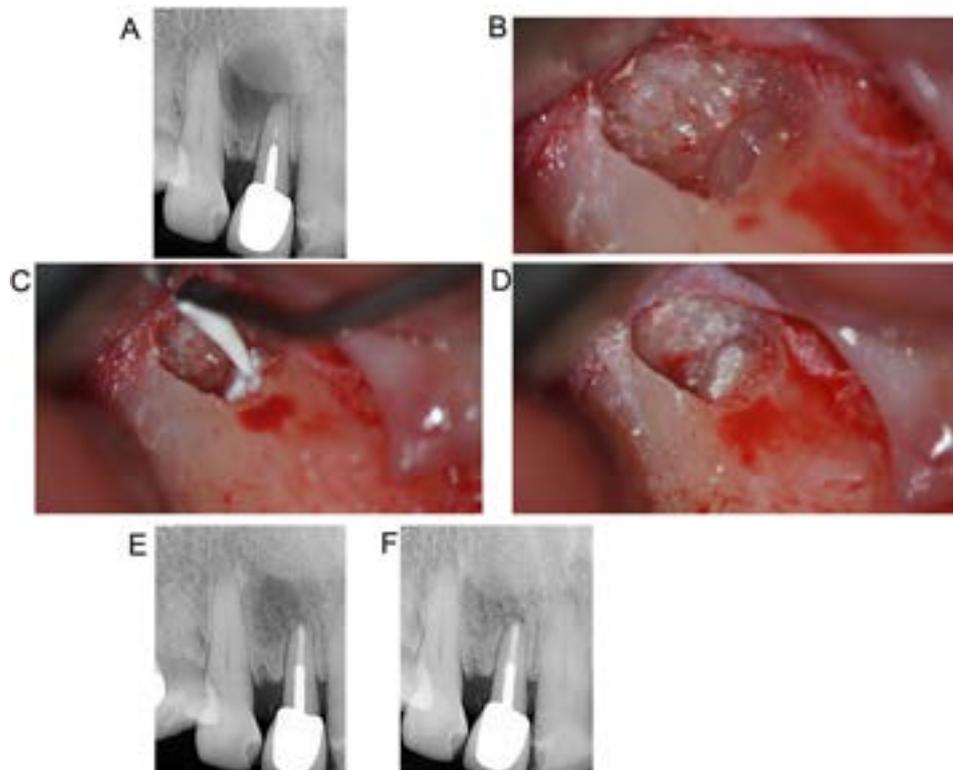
(A) Preoperative radiograph. (B) Post apicoectomy and retroprep. (C) Use of a BC putty over a retroprep cavity filled with BC Sealer. (D) Final placement and verification of BC putty retrofill. (E) Immediate postoperative radiograph, note the presence of BC Sealer along the post toward the coronal part. (F) 1-year-follow-up with advanced periapical healing. Courtesy of Dr. Gilberto Debelian.
